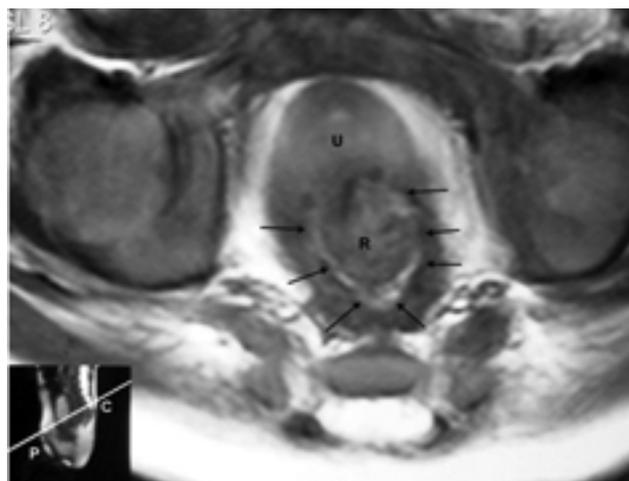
MRI: Puborectalis at level of P-C line.
